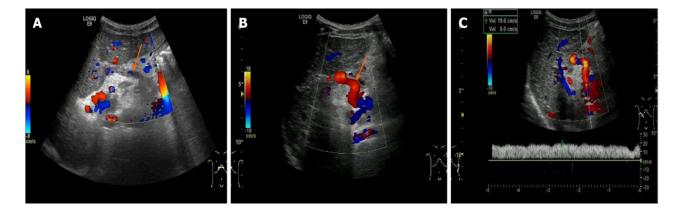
Color Doppler ultrasonography of a 7-year-old boy after classic Rex shunt (splenic vein-left portal vein shunt). A: Color Doppler flow imaging (CDFI) showed stellate blood flow signal in the bypass vessel (splenic vein) 7 d after operation; B: CDFI showed that the internal blood flow signal of the bypass vessel filling was good; C: Flow velocity of the middle part of the bypass vessel was 19.6 cm/s. Arrow indicates splenic vein.
